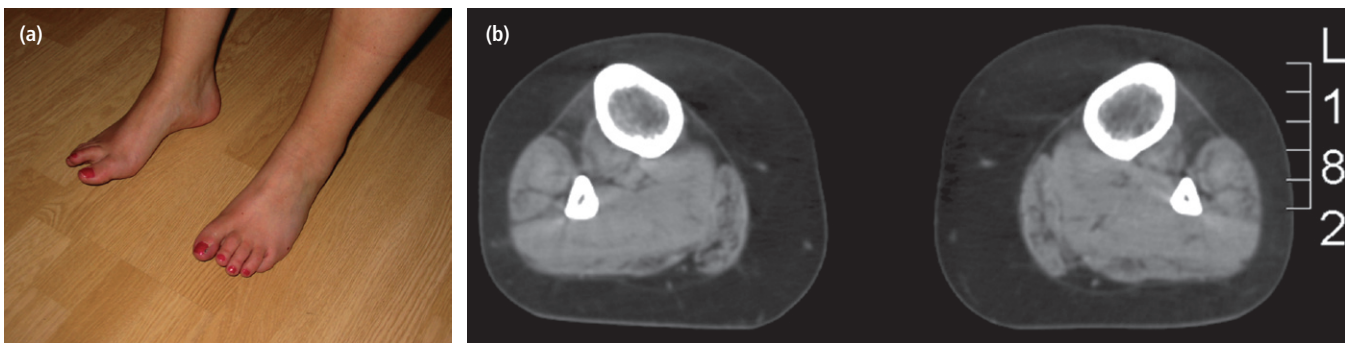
Laing early-onset distal myopathy. (a) Inability to lift the feet, hanging big toe on the right side. (b) CT scan of the lower legs showing fatty replacement of the foot and toe extensors, and to a lesser extent of the gastrocnemius muscles.
